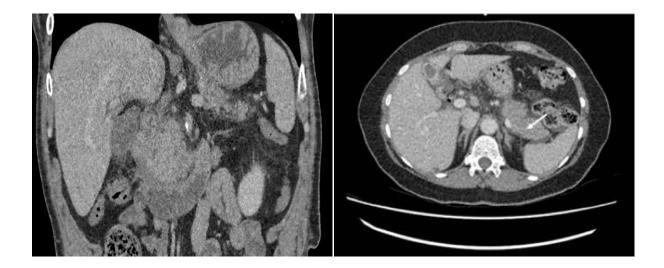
Abdominal (transverse section) CT image showing features of interstitial oedematous pancreatitis (left). There is oedema of the distal pancreatic region with peri-pancreatic fat stranding (arrow). On the right, CT with contrast: findings indicate the presence of pancreatitis with peripancreatic retroperitoneal fat stranding, specifically located around the head and uncinate process of the pancreas. There is also a noticeable focal enlargement and dilation of the bile duct.
